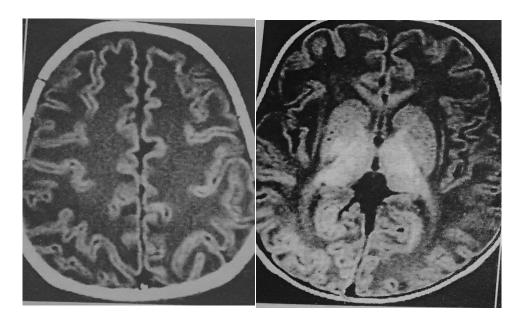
Non-contrast CT scan shows diffuse hypointensity along white matter, subcortical arcuate fibres sparing thalamus, basal ganglia with thinning of cortex
